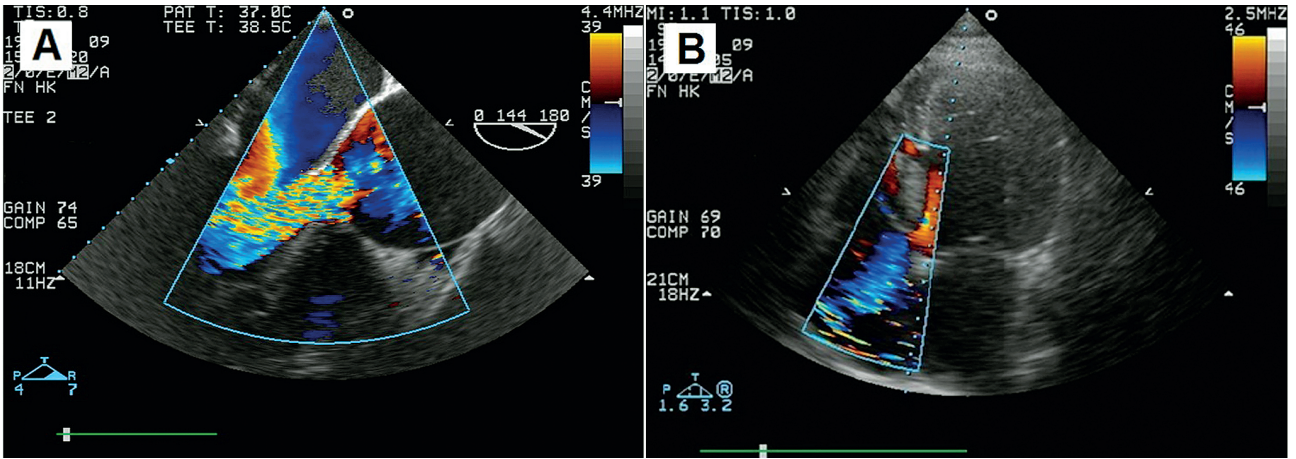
(A) A preoperative transesophageal echocardiogram with colour Doppler showing a giant aneurysm of the aortic root and adjacent ascending aorta with massive aortic valve regurgitation. (B) A preoperative transesophageal echocardiogram with colour Doppler showing a severe tricuspid regurgitation and mid-muscular ventricular septal defect.
